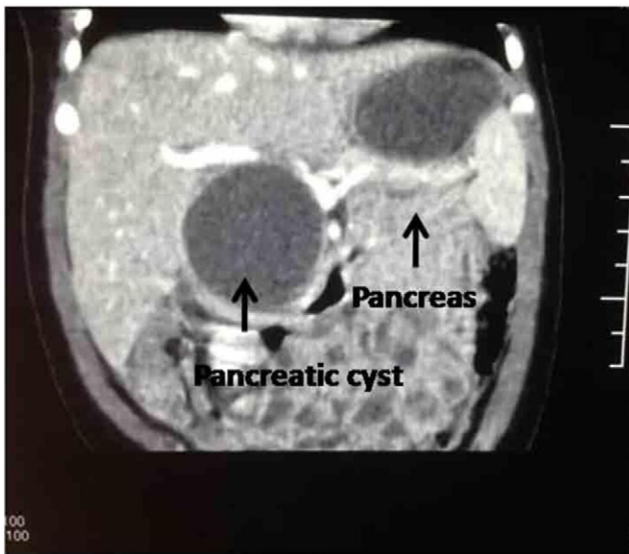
Pre-operative CT scan showed the location of pancreatic cyst.
